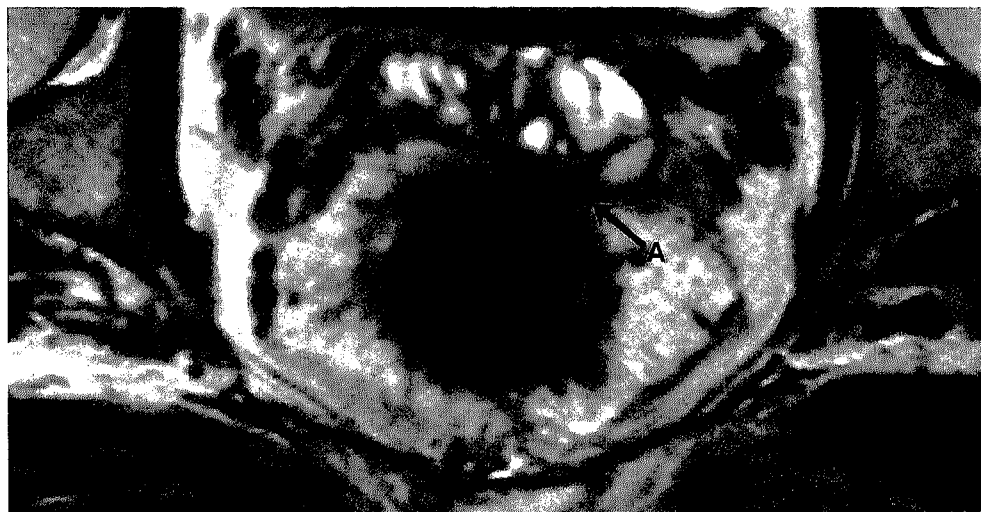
Corresponding axial T2W FSE (TR/TE 3427/150 ms) MR image shows that the tumor is invading the mesorectal fascia but not the seminal vesicles (A). So the tumor had been overstaged by CT again due to lack of contrast resolution.
